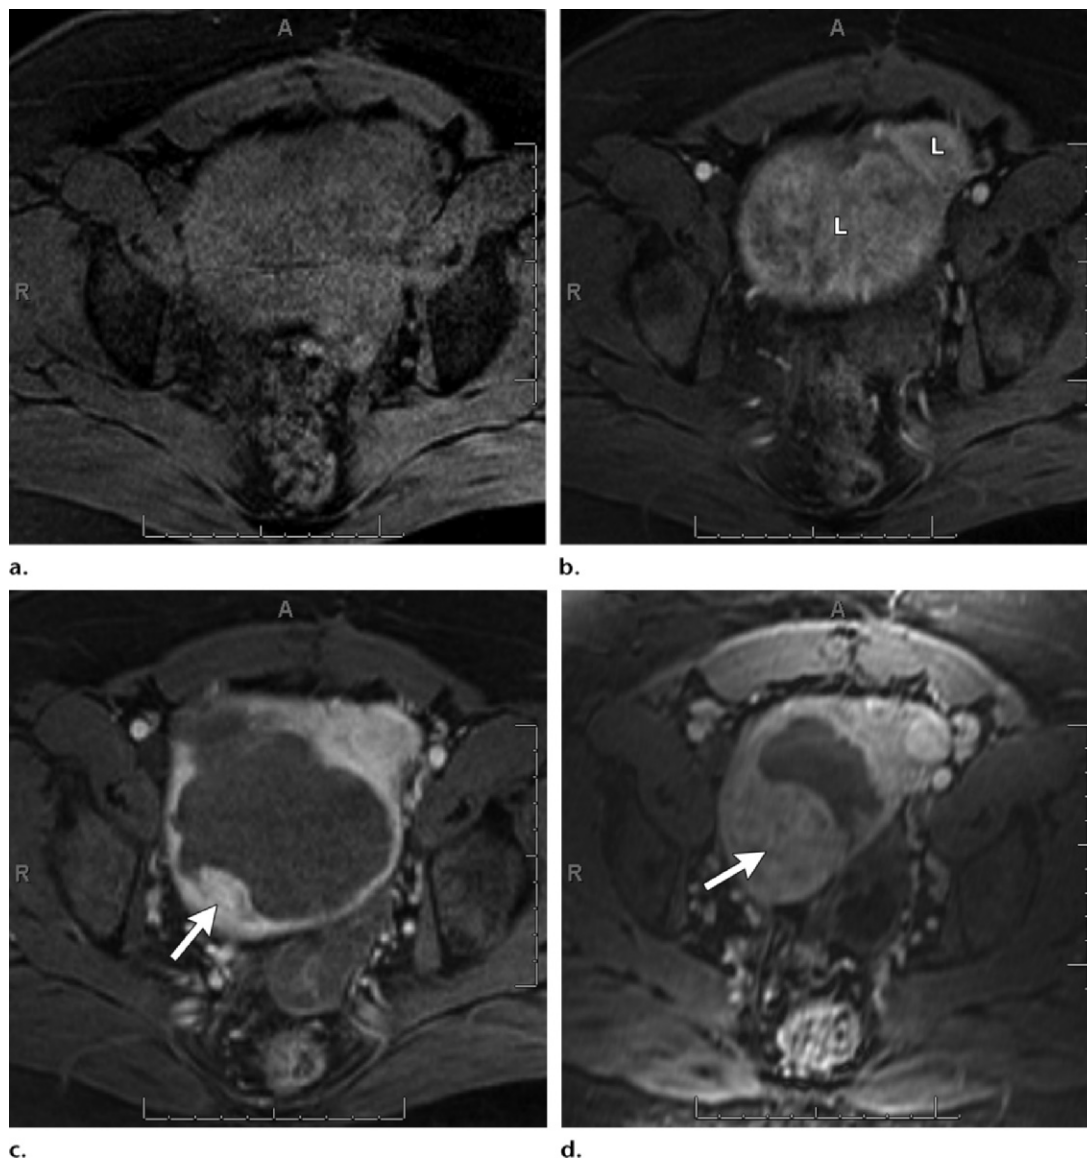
UFE failure due to regrowth. (a, b) Axial nonenhanced (a) and contrast-enhanced (b) fat-suppressed T1-weighted GRE images before UFE show two viable fundal leiomyomas (L in b). (c) Axial contrast-enhanced fat-suppressed T1-weighted GRE image after UFE shows residual viable tissue at the periphery of the larger leiomyoma (arrow) and homogeneous enhancement of the smaller leiomyoma. (d) Axial contrast-enhanced fat-suppressed T1-weighted GRE image obtained 3 months later shows regrowth of the large leiomyoma (arrow).
